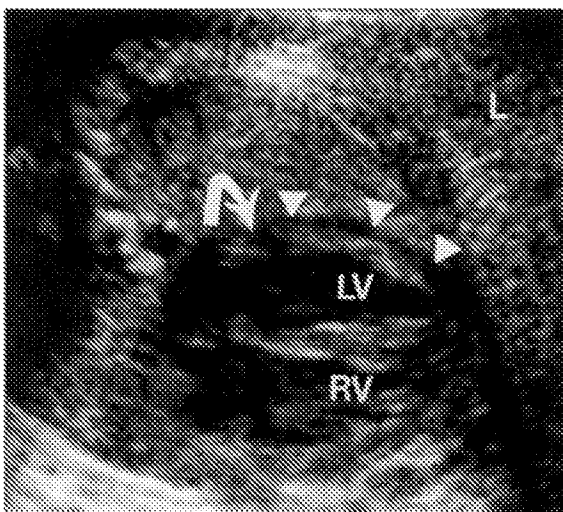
Pseudopericardial effusion in fetus at 30 weeks gestational age; fetus is in vertex position with right side down. Transverse sonogram of chest shows normal hypoechoic rim of myocardium (arrowheads). Note rim ends at level of mitral valve (arrow). LV = left ventricle, RV = right ventricle, L = fetal left side.
